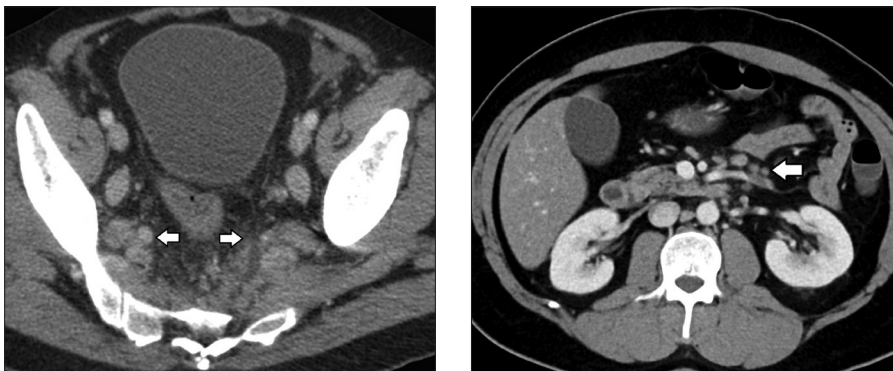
Axial CT image through the pelvic cavity in the same patient as in Fig. 10 shows bilateral internal iliac lymphadenopathy (*horizontal arrows*).
